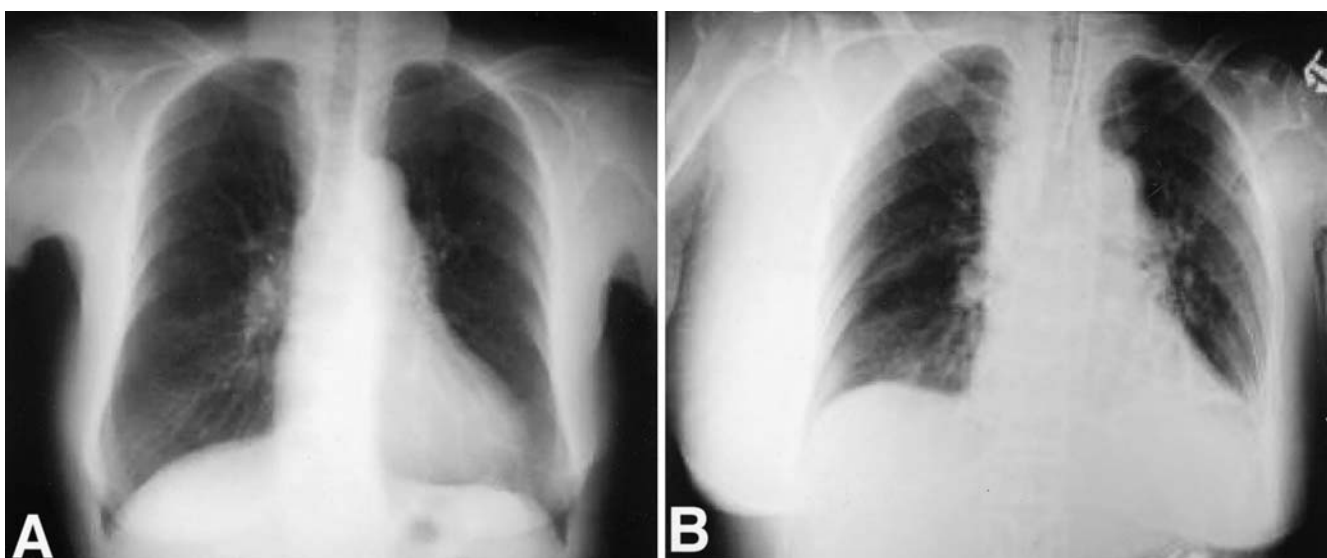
Chest X-ray films, before surgery with the patient in the upright position (A) and immediately after the end of surgery, in the supine position (B). Note that the image of the right thoracic soft tissues is enlarged after surgery
